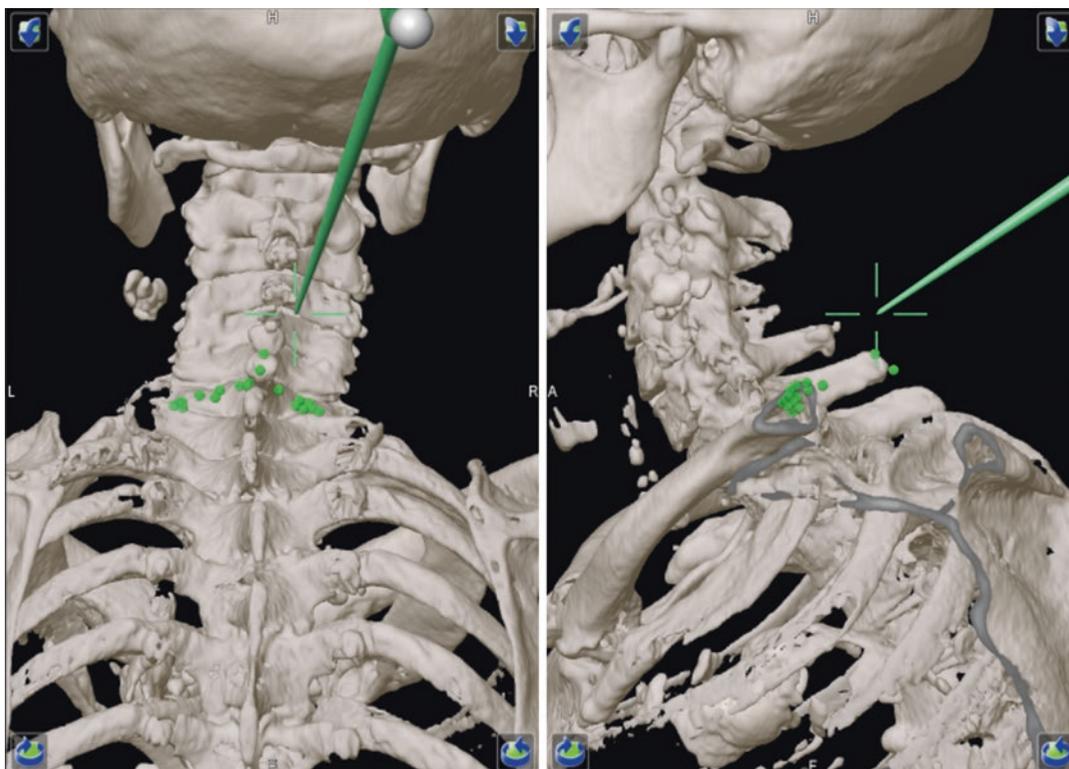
Point-by-point registration of a posterior cervical spine lamina for CT-region matching registration
